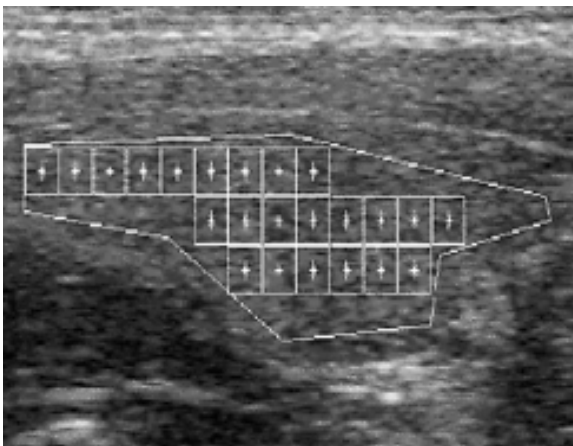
Sonographic image (longitudinal scan of right lobe) with drawn boundary of thyroid gland and texture samples (rectangular windows of 41x41 pixels).
